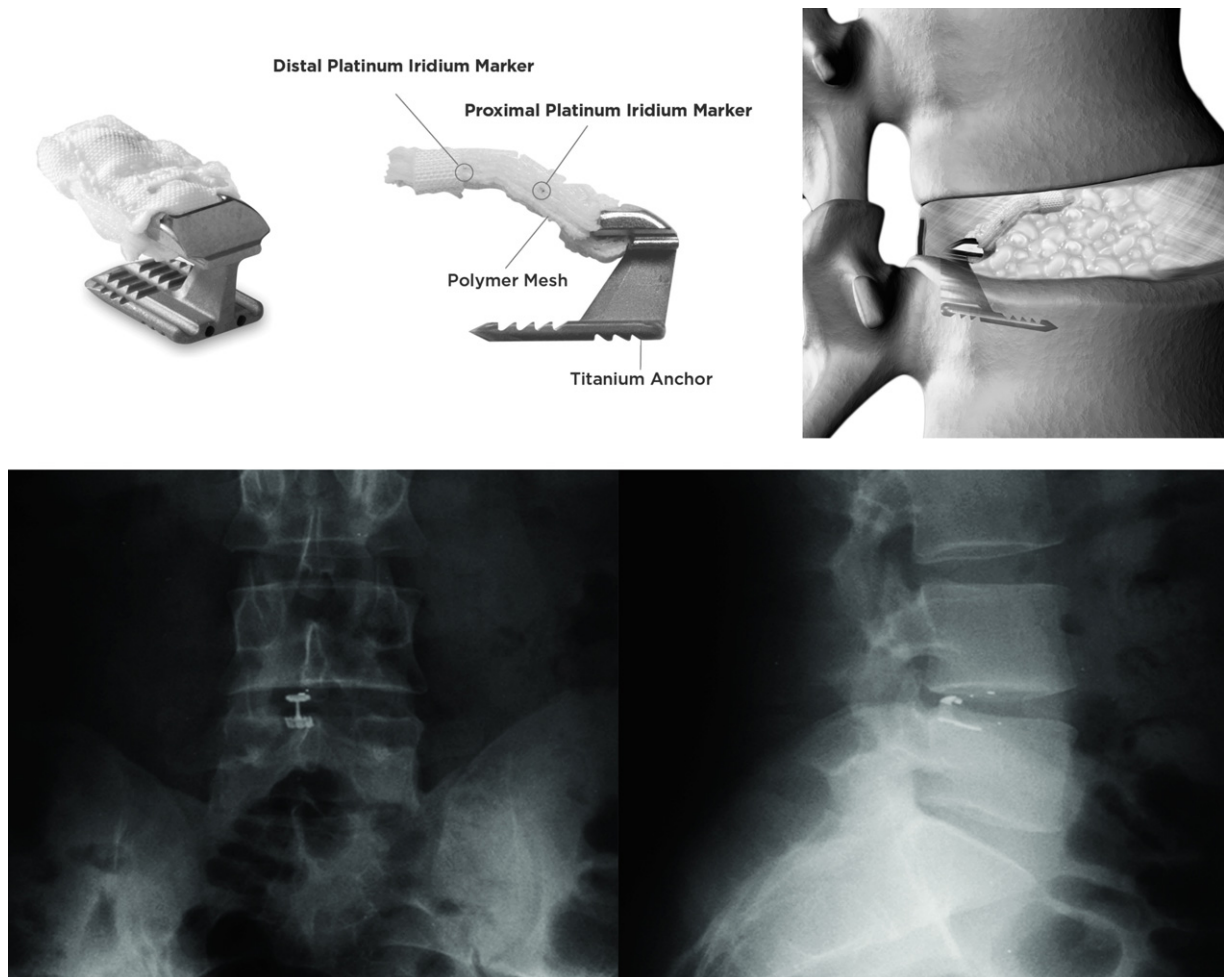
Barricaid device (upper left), representation of implanted position (upper right) and typical post-operative lateral and AP X-rays (below).
